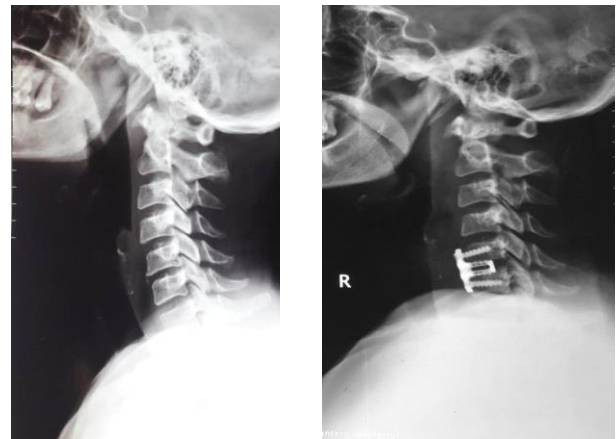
A – Nonunion after C5/6 fusion- Lateral Radiographs (A) preop, (B) Postop,(C) at 2 yrs,(D) Extension and (E) Flexion images .Flexion pronounces defect in the bridging bone and radiolucency around the implant.
